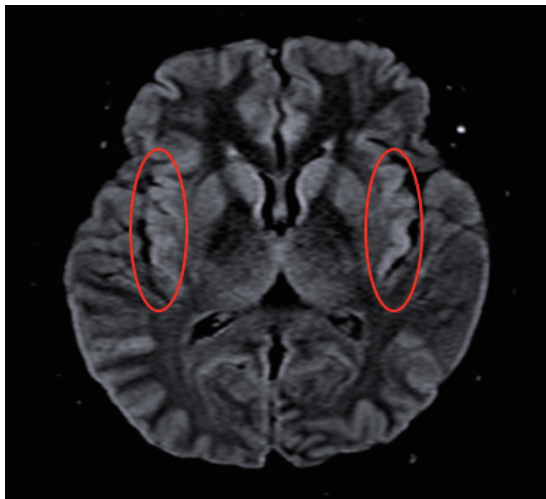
MRI of the brain showing areas of T2 fluid attenuated inversion recovery (T2 FLAIR) hyperintensities involving the bilateral insula and mesial temporal lobes.
